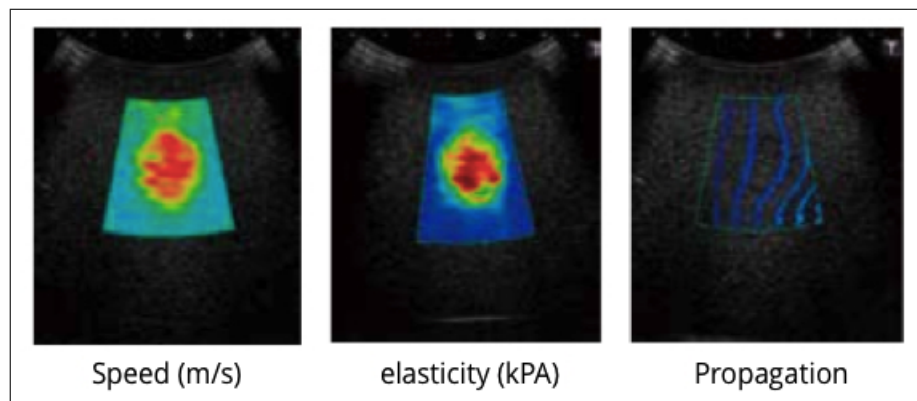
Three different display modes of Toshiba Applio 500 ultrasound system.
